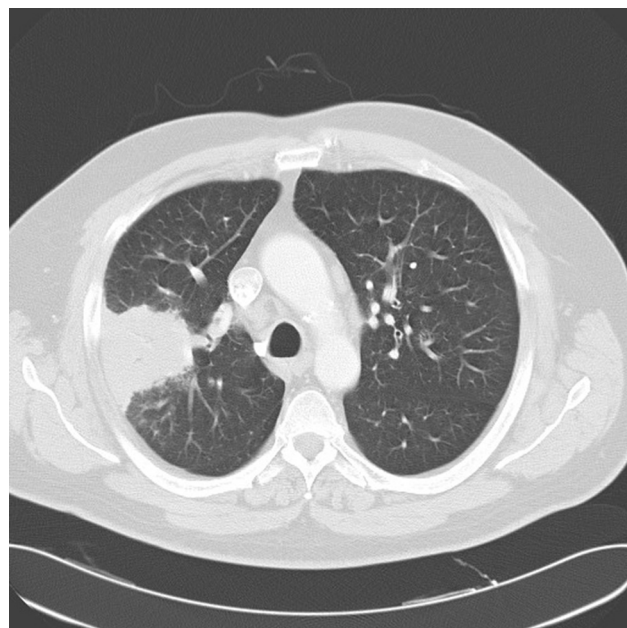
Chest CT image of right upper lobe.
